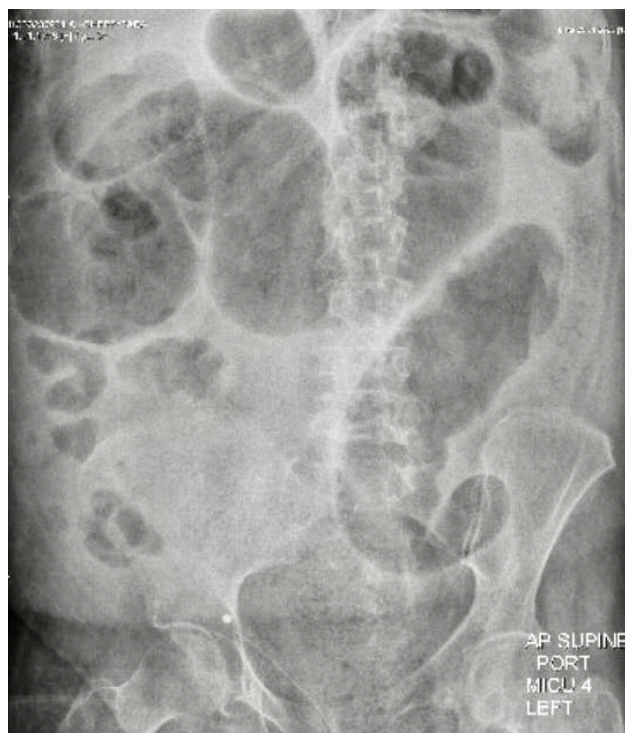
Abdominal X-ray showing multiple dilated large bowel loops loaded with faeces.
